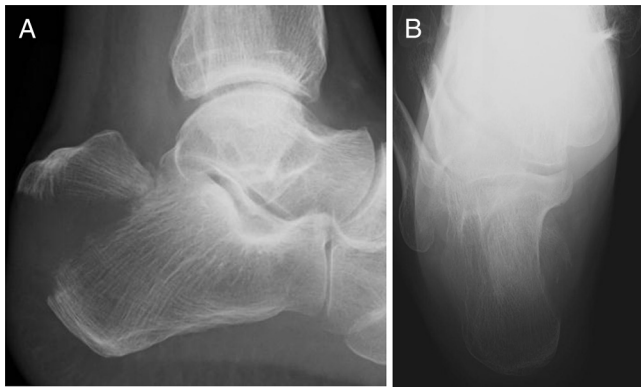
Plain (A) lateral and (B) axial radiographs showing a calcaneal avulsion fracture (Beavis type 2).
